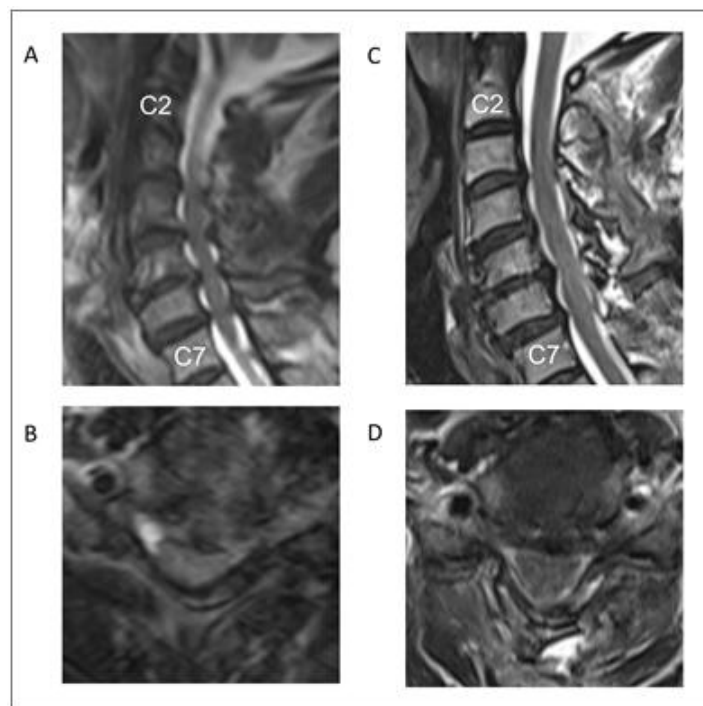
MRI findings of the cervical spine before and after nerve decompression. T2-weighted images.
